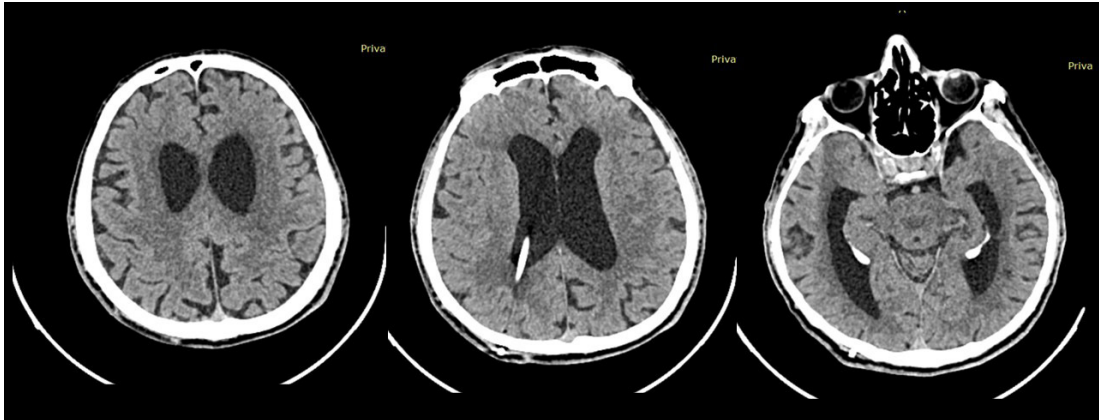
Pos-op cranial CT showing partial resolution of hydrocephalus.
